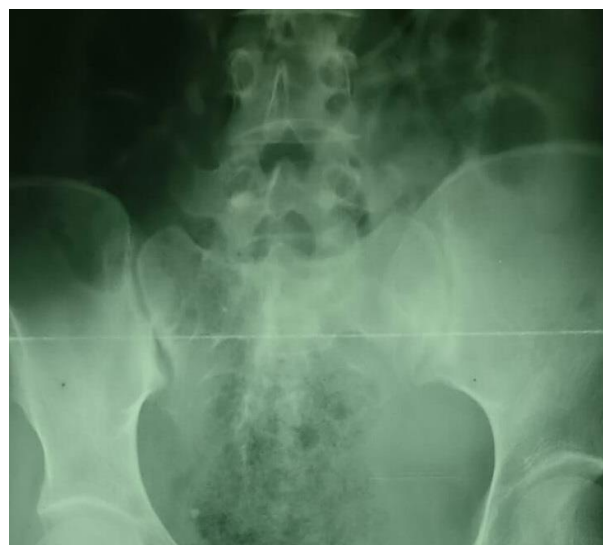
X-ray showing sacroiliitis
